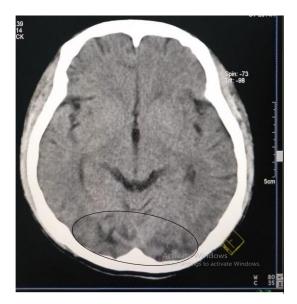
CT-Scan Examination Result of Head without Contrast showing Edema Vasogenic in Regio Parieto-Occipital (signed with black circles)
